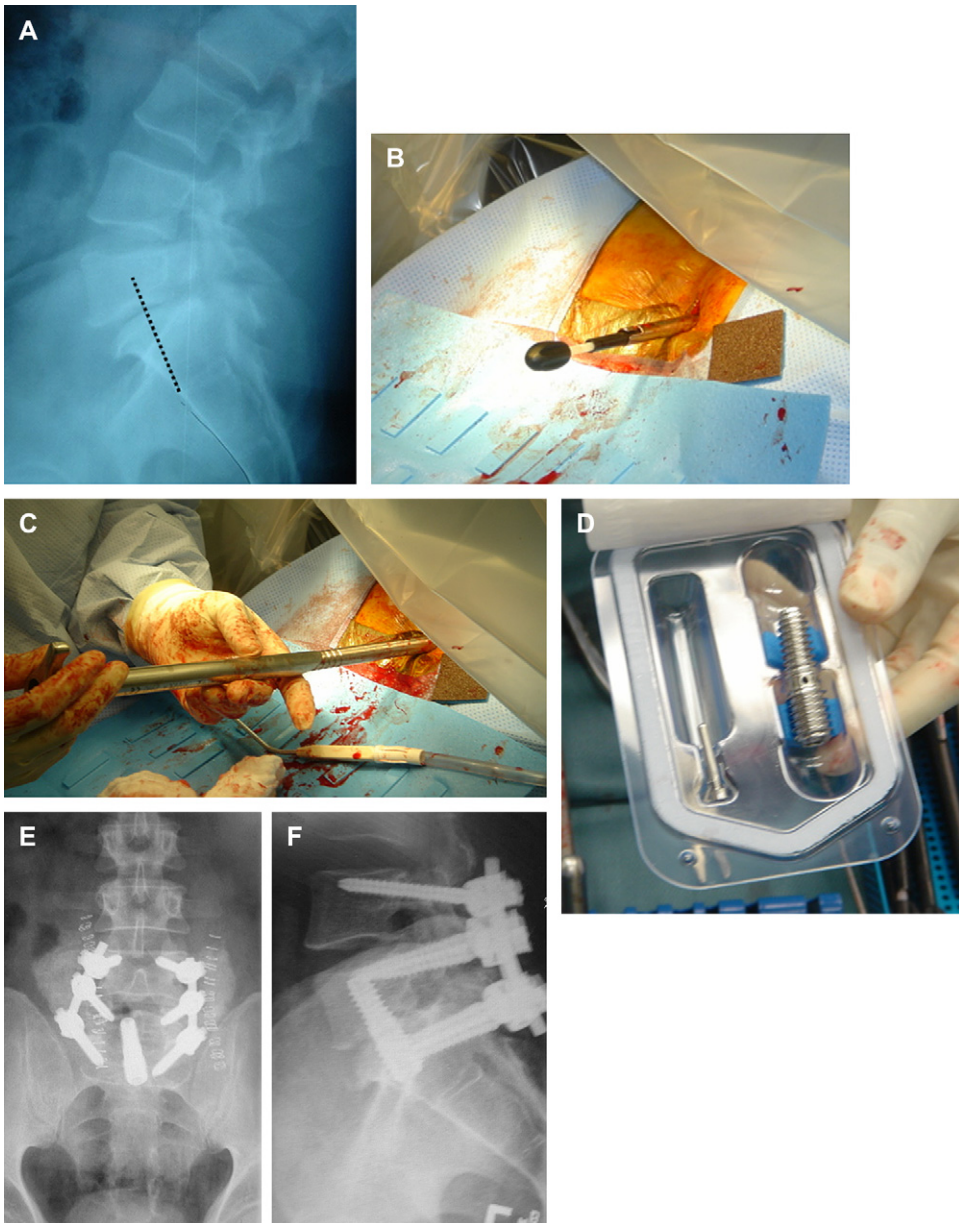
(A) Preoperative lateral plain radiograph addressing the L5–S1 interspace through an AxiaLIF approach using the presacral space. (B) Intraoperative photograph demonstrating the introducer assembly inserted through a small paramedial incision. (C) Intraoperative photograph demonstrating the final dilator sheath in place. (D) Photograph demonstrating the differential pitch of the AxiaLIF threaded rod, which allows for distraction across the disc space during intraoperative insertion. AP (E) and lateral (F) postoperative radiographs of the AxiaLIF threaded screw in place addressing the L5–S1 interspace with corresponding L4–S1 pedicle screw fixation.
